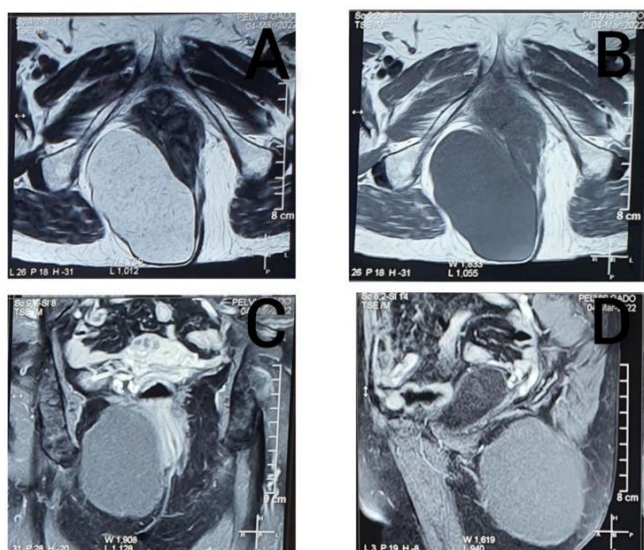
Selected cuts from the MRI
